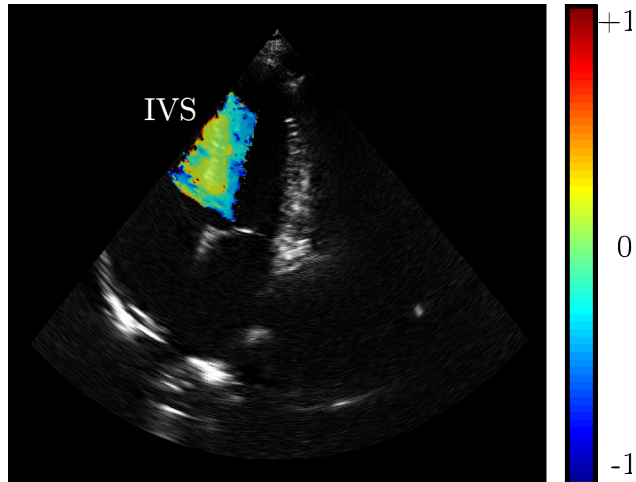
Example of a B-mode echocardiography frame with the normalized color TDI velocity of the IVS shown. Positive (red) values indicate motion toward the transducer.
